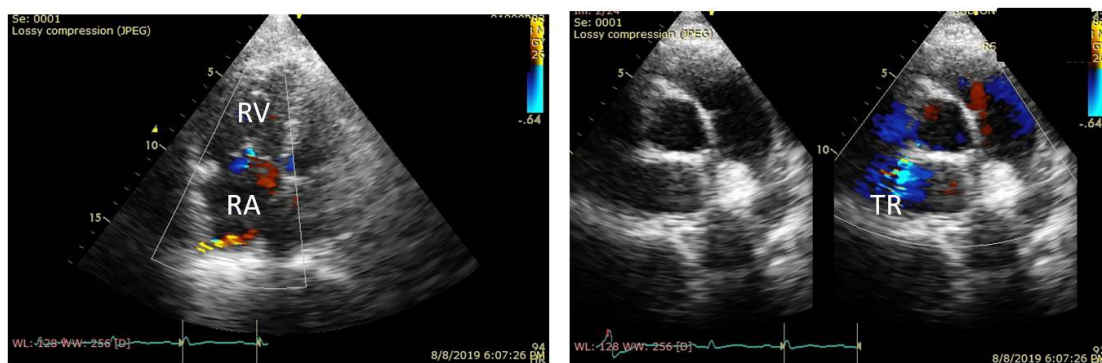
A transthoracic echocardiography appeared a jet of tricuspid regurgitation (TR) and right atrial (RA) and ventricular (RV) dilatation, a sign of a high probability of PH.
